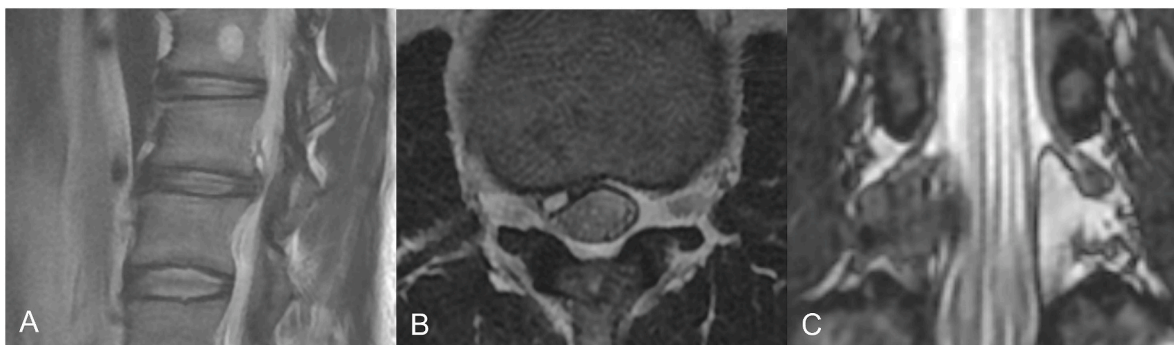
MRI on T2-weghted images three months after the operation: A, B, C, the L2 nerve root and the dural sac are sufficiently decompressed.
